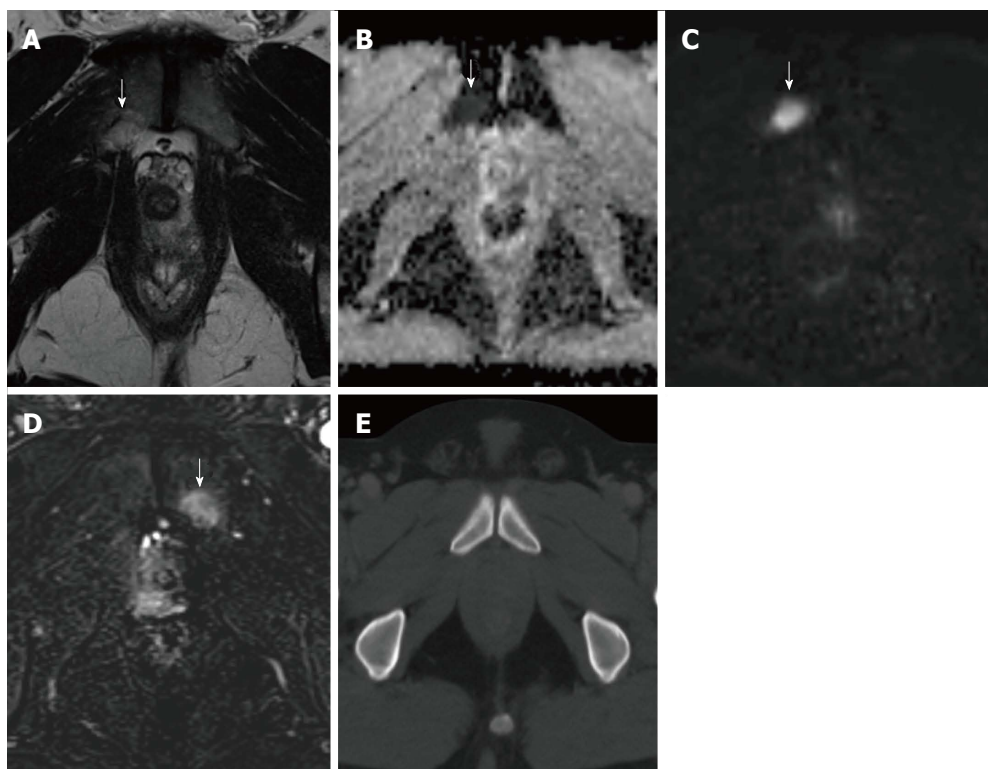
A 54-year-old patient with recently diagnosed prostate carcinoma. A: T2-weighted axial image of the pelvis shows an ill-defined hyperintense area in the right pubis (arrow); B and C: ADC map (B) and DWI images (C) show restriction of diffusion in the same area (arrow); D: DCE image presents enhancement of the lesion after IV gadolinium (arrow). MRI findings were suspicious for pelvic bone metastasis, with no evidence of such lesion on staging abdomino-pelvic CT scan performed a week earlier (E) and in a previous bone scintigraphy (not shown). Bone metastasis was confirmed on clinical evolution. MRI: Magnetic resonance imaging; DCE: Dynamic contrast-enhanced; CT: Computed tomography.
